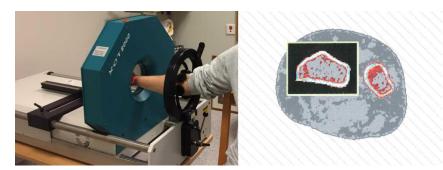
Peripheral quantitative computed tomography (pQCT)
